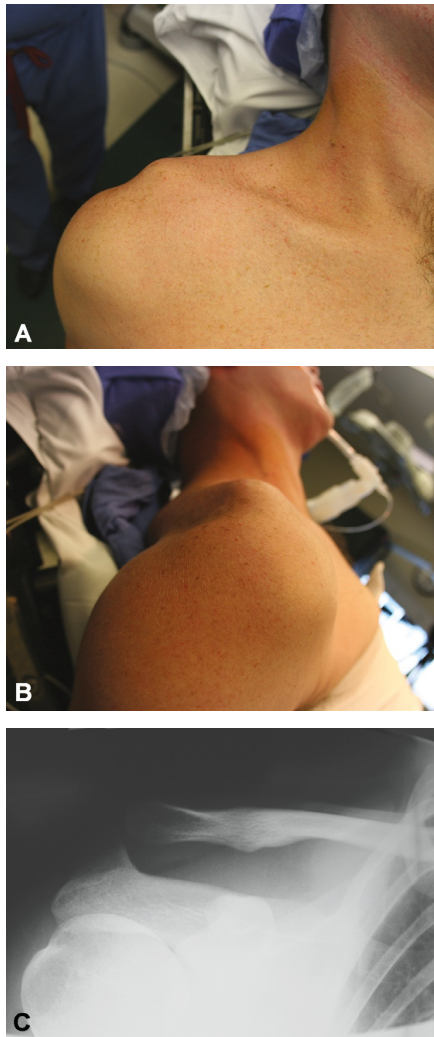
Typical findings after a type V AC joint injury, anterior view (A) and lateral view (B). There is a twofold to threefold increase in the coracoclavicular distance as well as a stripping of the deltoid and trapezial fascia from the clavicle. This patient was unable to reduce the AC joint with an active shoulder shrug, indicating a true type V injury instead of a type III injury. C, Anteroposterior radiographic view demonstrates widening, evidence of a type V injury. (From Miller MD, Thompson SR: *DeLee & Drez's orthopaedic sports medicine: Principles and practices*, ed 3, Philadelphia, 2010, Saunders.)
